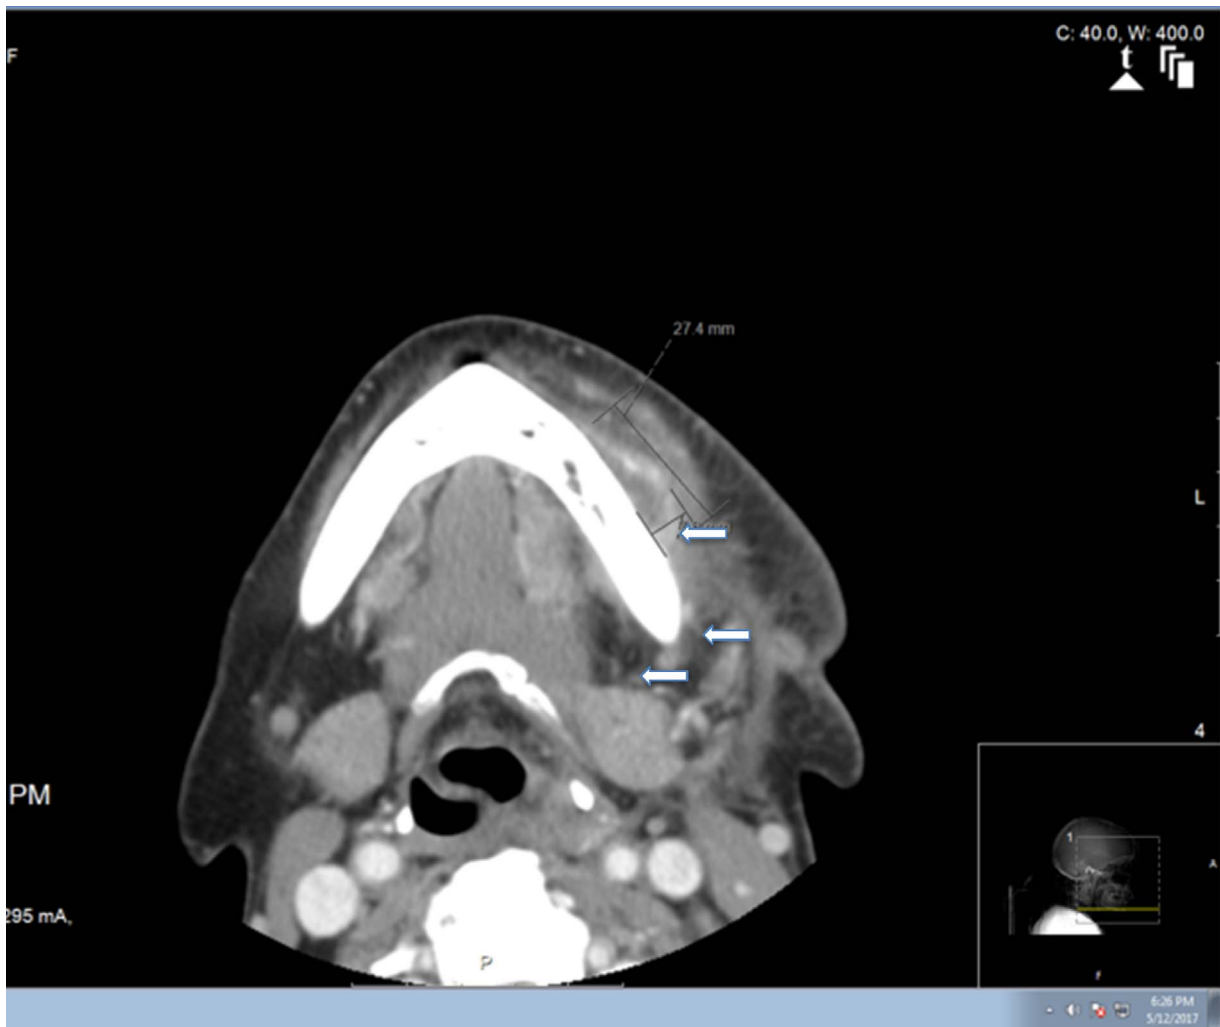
Fig. 5 depicts a CT Soft Tissue Axial View. A focal fluid collection is present along the left mandibular body and in the left masseter muscle without significant wall enhancement. Edematous enlargement of the left masseter and pterygoid musculature are evident (white arrows).
